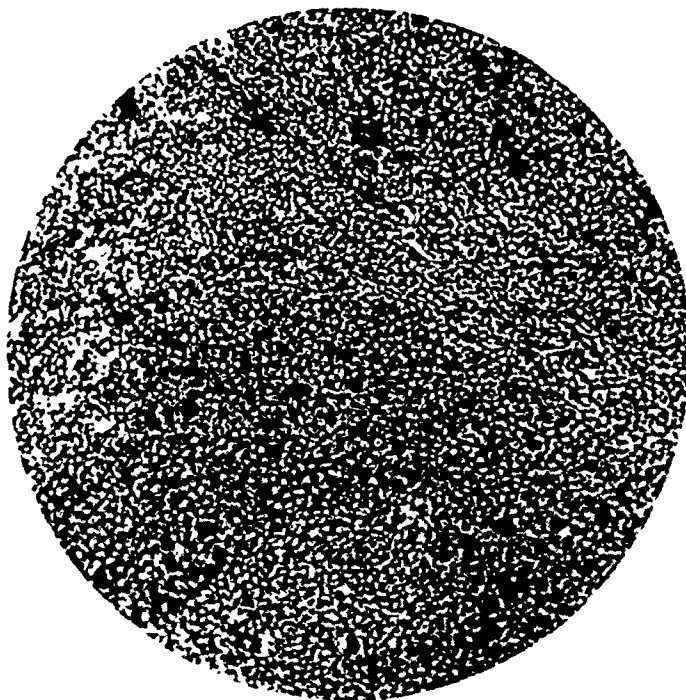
Case 15. Tonsil. Before toxin treatment. Inoperable lymphosarcoma of tonsil and neck. Nearly disappeared after two months' toxin treatment, but then increased rapidly. Removed by operation, and toxin treatment again given. Improved under radium and X-ray; later recurred. Still under treatment.
